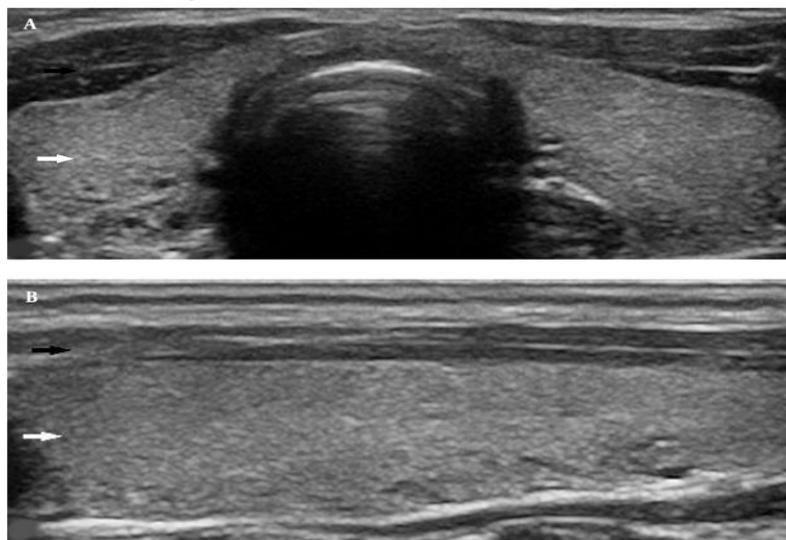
A, Transverse; and B, Sagittal gray-scale ultrasound images of thyroid gland showing homogeneous echogenicity of normal thyroid parenchyma (white arrow) (3)
